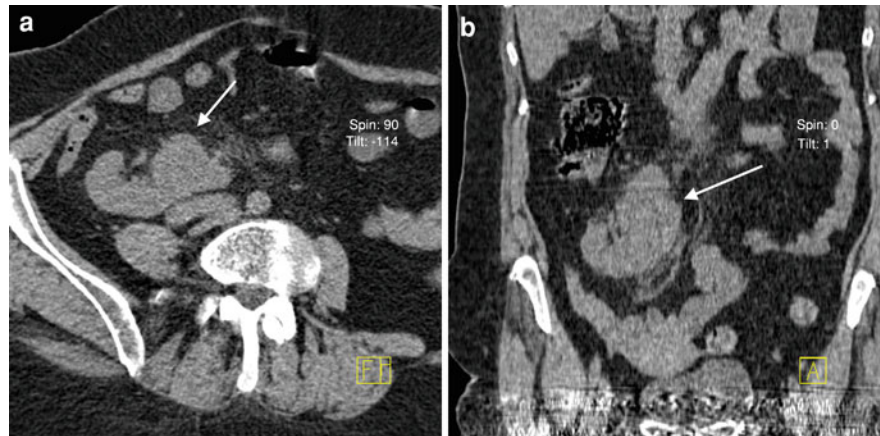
a, b Transverse CT images obtained without any contrast (neither oral nor IV) in a patients suspected of acute appendicitis with a definite diagnosis of cecal neoplasia (a
